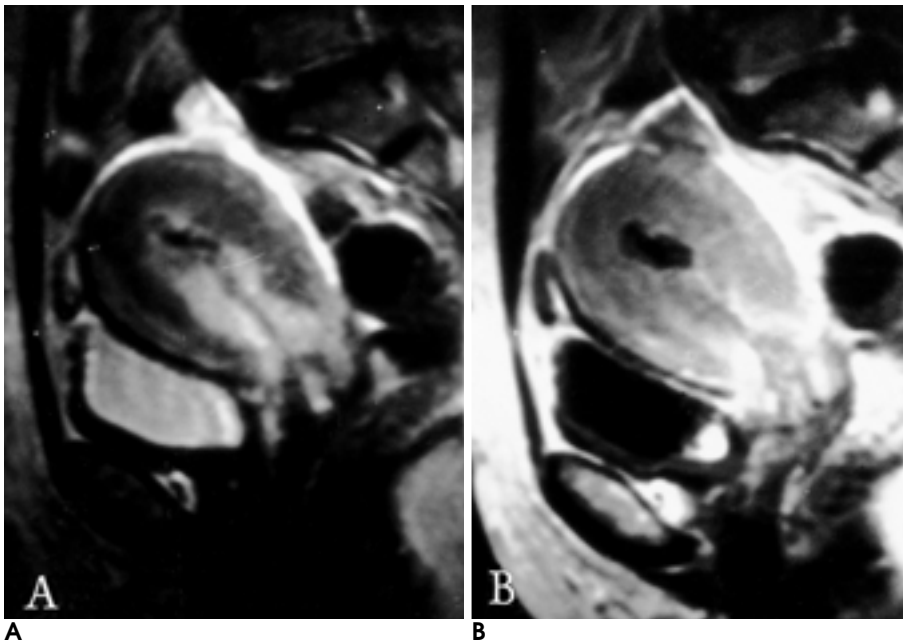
Endometrial carcinoma penetrating beyond the serosa shows invasion of full-thickness of the uterine cervix on sagittal T2-weighted image(A) and fat-suppressed Gd-enhanced T1-weighted image(B).
